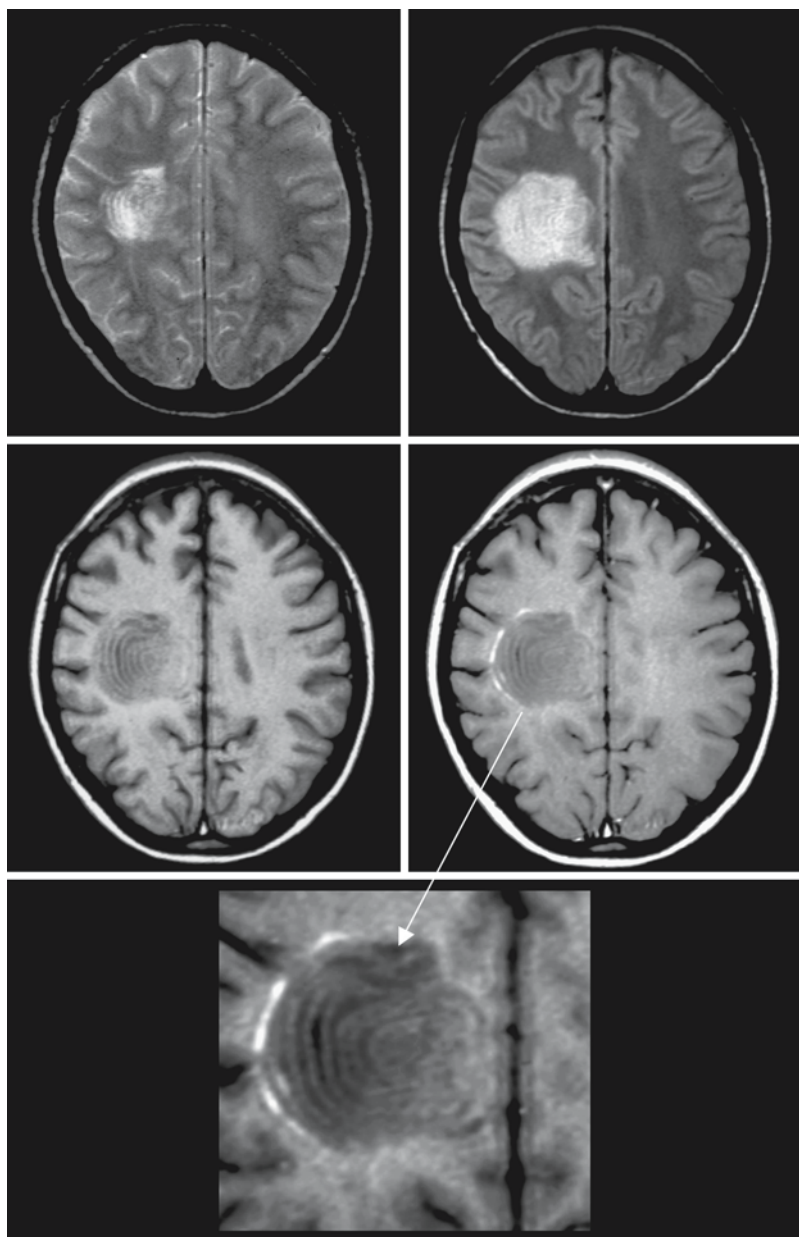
A 25-year-old woman with CS. MRI shows a large lesion with a concentric pattern of rings in the white matter of the centrum semiovale on the right side. There is an abrupt termination of the concentric rings where the lesion abuts on the gray matter. After contrast injection only the outer rings enhance. From Korte et al. (1994), with permission
